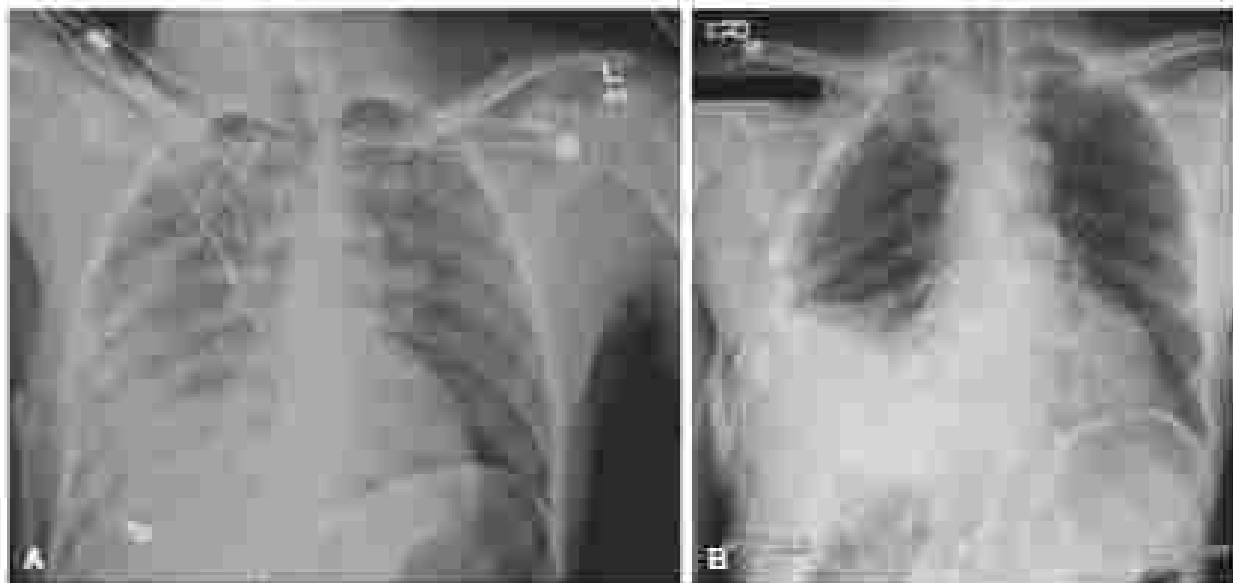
(A) Chest radiograph to detect liver injury after gunshot wound to right thoraco-abdominal region (B) Chest radiograph to detect liver injury after blunt trauma to right thoraco-abdominal region with multiple rib fractures and ball chest
